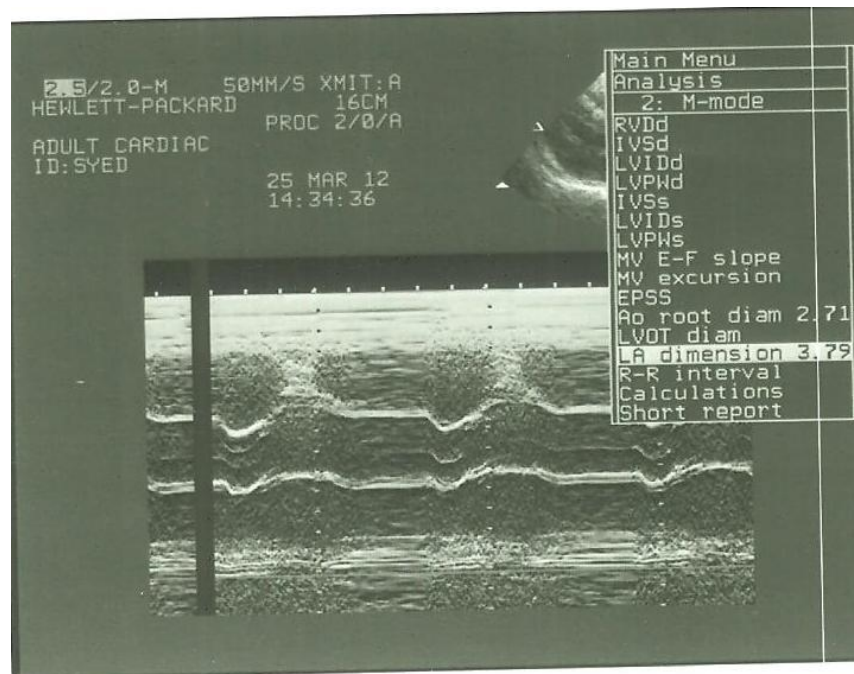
resting echocardiogram showing left atrial diameter =3.79 cm
